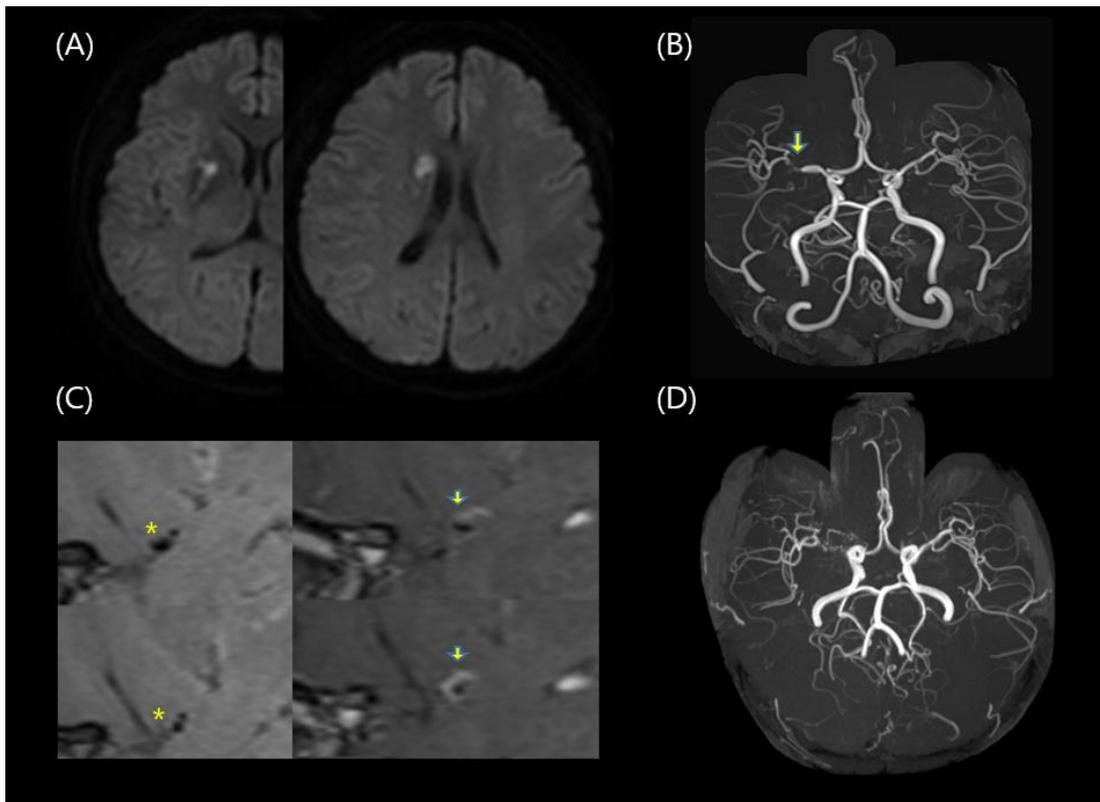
Magnetic resonance imaging and magnetic resonance angiography findings of patient with rs112735431 polymorphism
